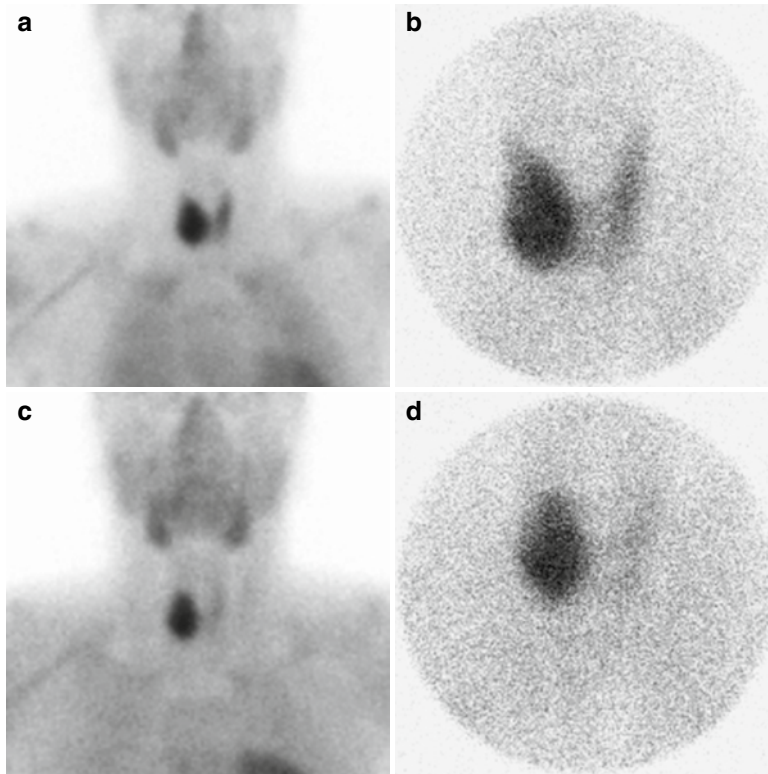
Parathyroid carcinoma evaluated with dual-phase ^{99m}Tc -sestamibi scintigraphy. Early-phase planar image of the upper torso (a) and pinhole image of the neck (b) both show intense uptake in a large mass in the right thyroid bed and moderate uptake in the left lobe of the thyroid gland. A planar image of the torso acquired at 105 min (c) and pinhole image of the neck acquired at
